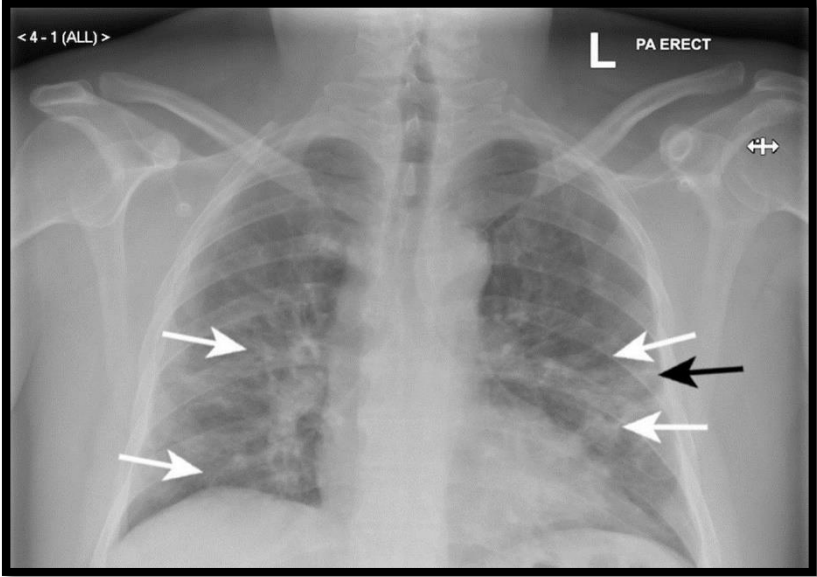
Covid-19 X-Ray [9].
